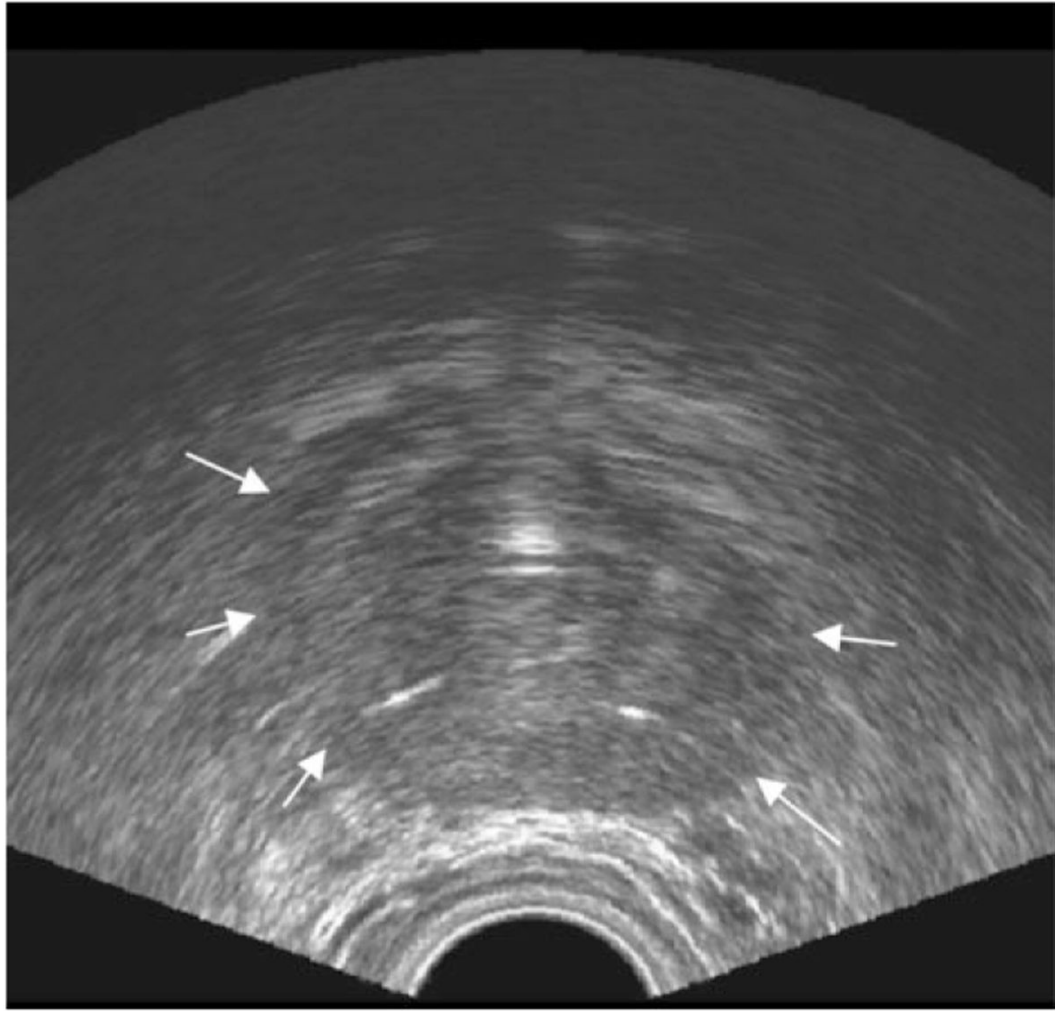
Prostate ultrasound. Axial transrectal ultrasound image of the prostate. Arrows indicate prostate capsule boundary.
